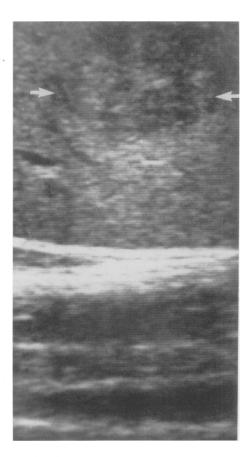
Metastatic lesion. A metastatic lesion (arrows) is identified. This clinically unsuspected lesion has mixed, but mostly hypoechoic, sonographic characteristics and is irregularly marginated.
